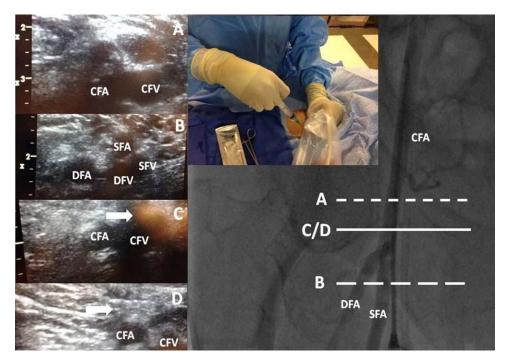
Ultrasound-guided transfemoral access technique and correlation with femoral angiography. Panel A: Visualization of both the common femoral artery and vein. Panel B: Visualization of vascular structures below the bifurcation of the common femoral artery and vein. Panel C: Ultrasound guided access of the common femoral vein using a micropuncture needle (arrow). Panel D: Ultrasound guided access
